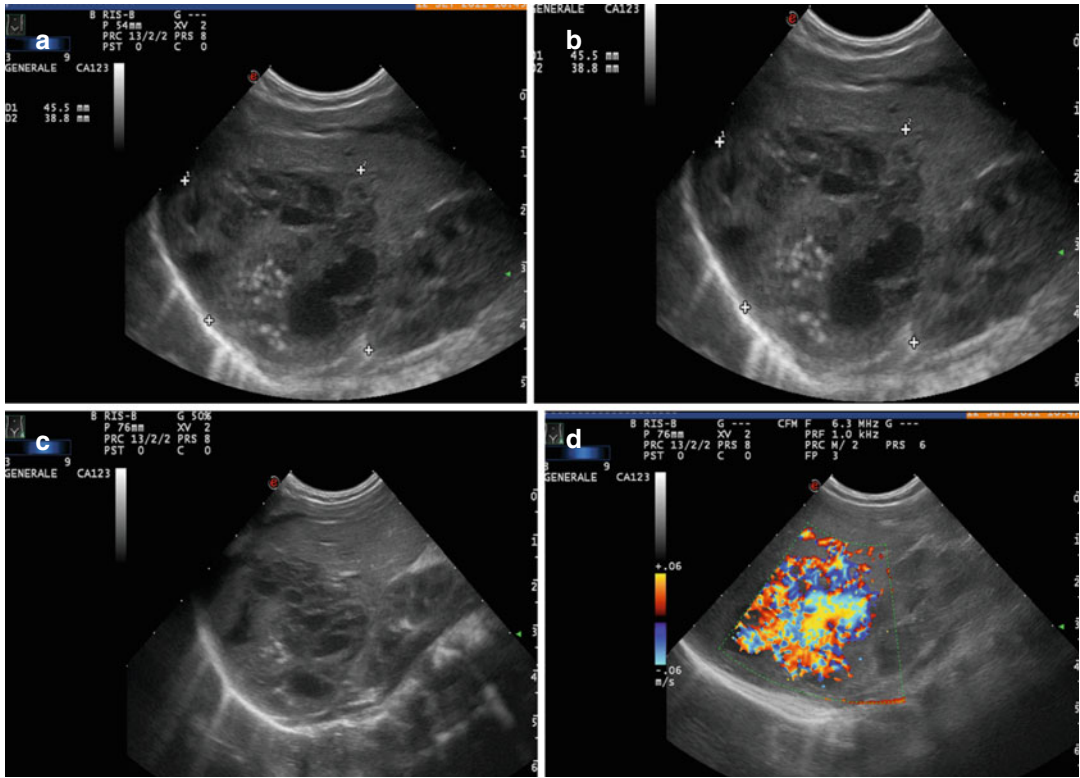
Male, 8-day years old. He arrives with a palpable right-upper quadrant mass and a prenatal diagnoses of adrenal mass. The US images show a solid hepatic lesion with a heterogeneous echotexture, but predominantly hypoechoic. Doppler colour flow (d) is marked for the presence of multiple AV shuntings
